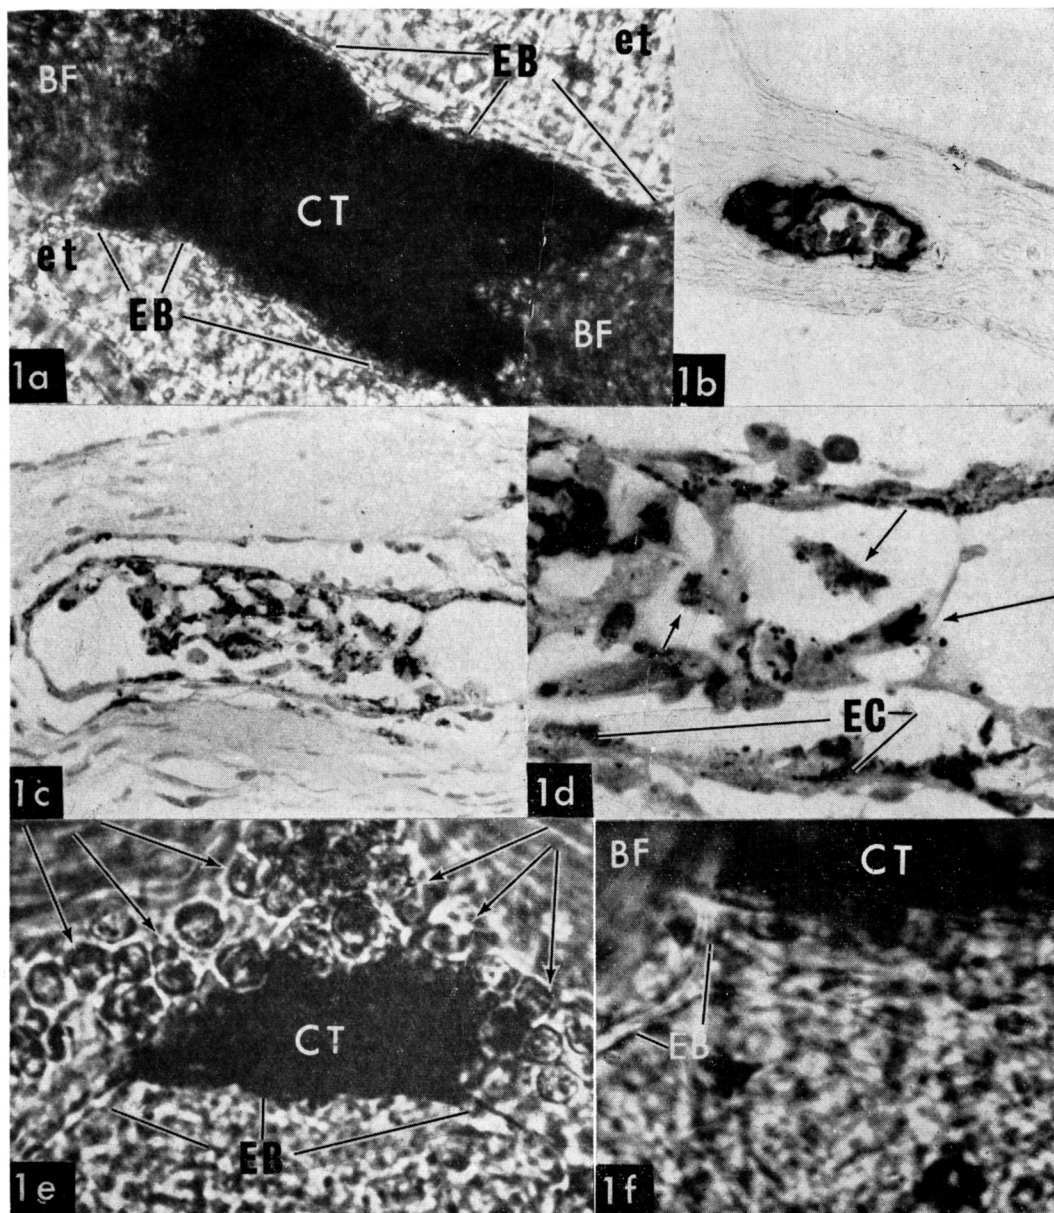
a. Photograph of a venule with a laser lesion *in vivo*, showing carbon sticking at 3 hr. Note blackening of lesion, rather well defined endothelial borders, clear extravascular tissue and blood flow proximal and distal to the lesion. CT = carbon thrombus; BF = blood flow; EB = endothelial border; et = extravascular tissue. $\times 210$.
